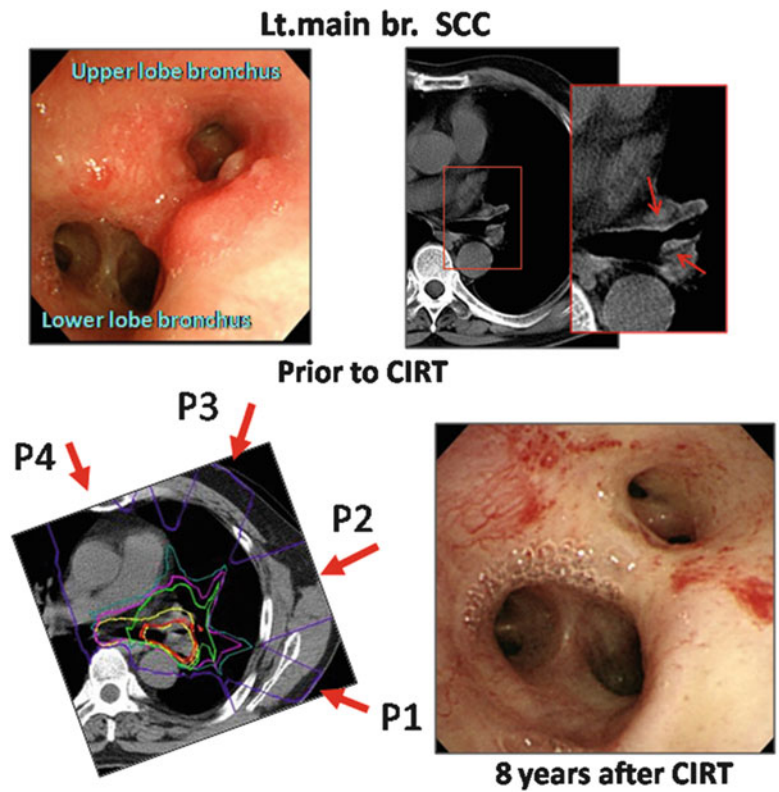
The planning CT showing the four-portal irradiation. CT and endoscopic images taken pre- and post-therapy are shown. The *arrow* indicates the tumor
